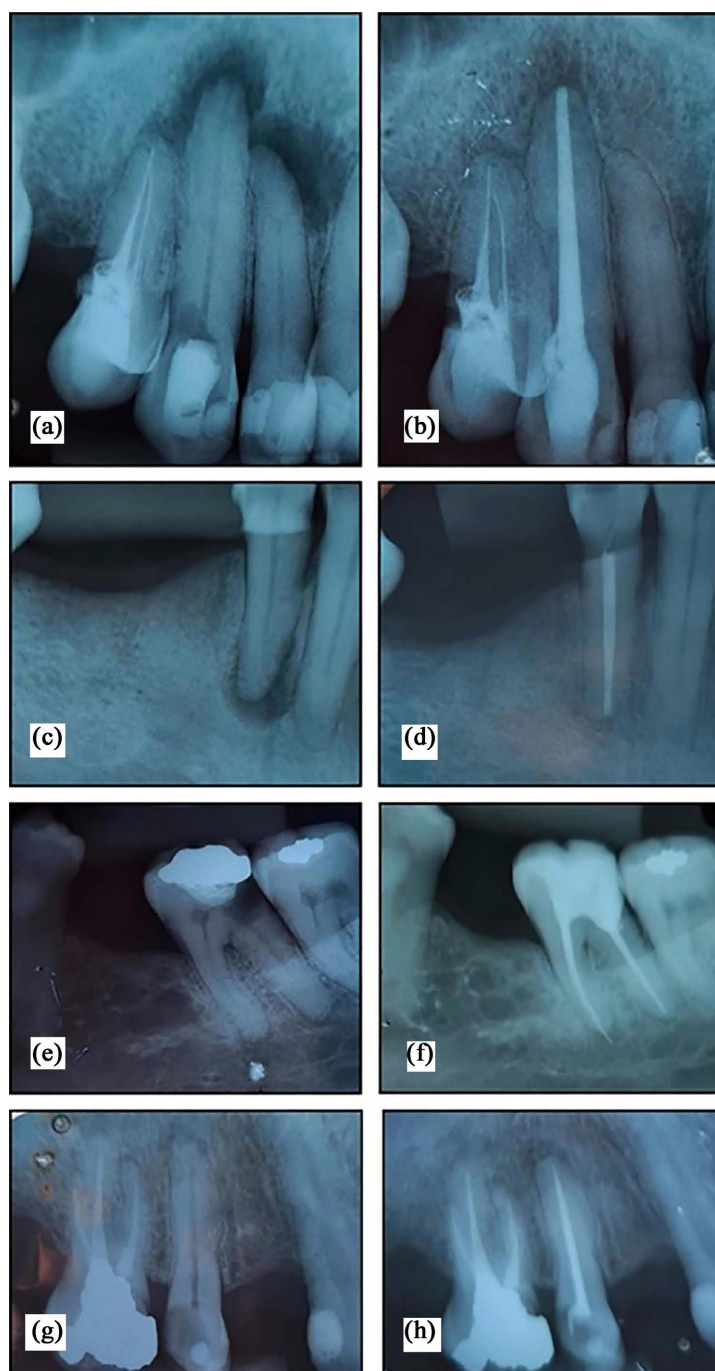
(a) Diagnostic radiography of element 13 with chronic apical periodontitis. Unit 12 reacted positively to the vitality test. (b) Follow-up radiograph 19 months after completion of nRCT demonstrating successful therapy with incomplete healing. (c) Diagnostic radiograph of unit 44 shows chronic apical periodontitis. (d) Follow-up radiograph 29 months after completion of the nRCT showed successful therapy and regression of the periapical lesion even with provisional GIC restoration. (e) Diagnostic radiograph of unit 36 shows chronic apical periodontitis. (f) Follow-up radiograph taken six months after completion of the nRCT showing root canal overfilling in the mesial root in a patient with lupus. (g) Diagnostic radiograph of unit 15 shows chronic apical periodontitis. (g) A 20-month follow-up radiograph after completion of the nRCT demonstrating the failure of therapy due to increased periapical lesion.
